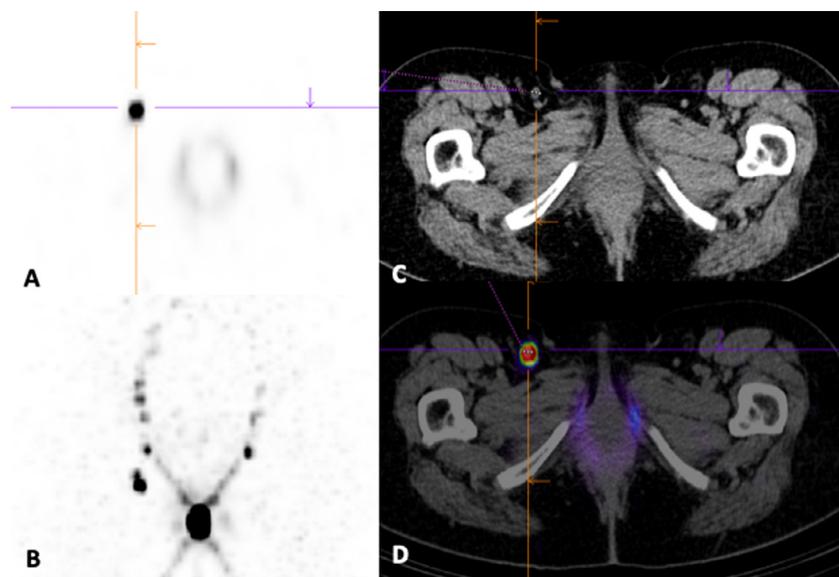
A 63-year-old woman, before surgery for vulvar carcinoma, underwent sentinel LN scintigraphy after injection of about 40 MBq of ^{99m}Tc nanocolloid in two peritumoral points, followed by planar images acquisition (not shown). Several focal uptakes were observed in planar acquisitions while the SPECT/CT (A-axial view of SPECT, B-MIP, C-axial view of CT, D-axial view of fusion) localized the uptakes in two sentinel millimetric bilateral inguinal LNs. During surgery, three sentinel LNs were harvested on the right groin, all negatives, and one in the left groin, negative as well.
